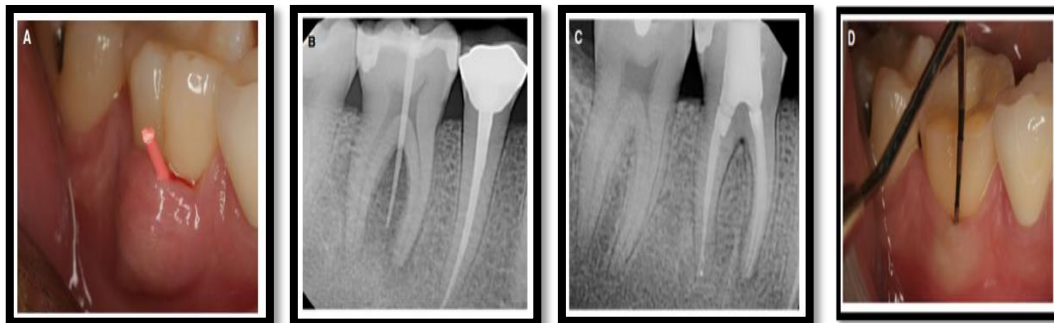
Mandibular first molar with necrotic pulp presents with primary endodontic disease. (A) Gutta-percha cones are used to track abscesses on the buccal surface of teeth. (B) Radiation-impermeable mesial and distal root and bifurcation root cyst radiographs. (C) Four months after root canal treatment, x-rays show active bone healing. (D) Buccal periodontal defect is clinically healed and probing is normal.
